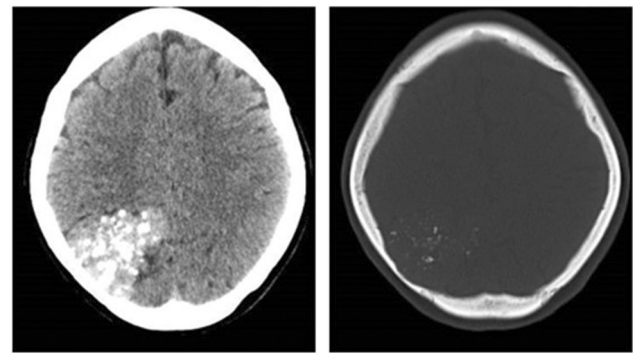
CT scan without contrast.
